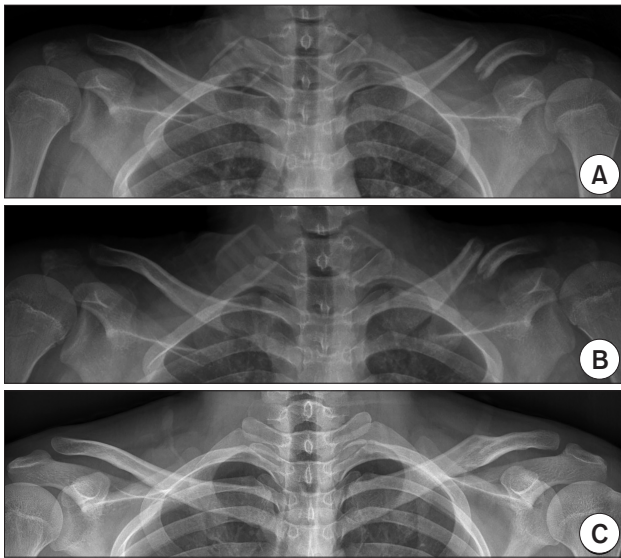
(A) Preoperative anteroposterior simple radiograph of a displaced midshaft fracture of the left clavicle in a 13-year-old boy. (B) The figure-of-8 brace was applied. (C) Bony union was achieved at the final follow-up.
